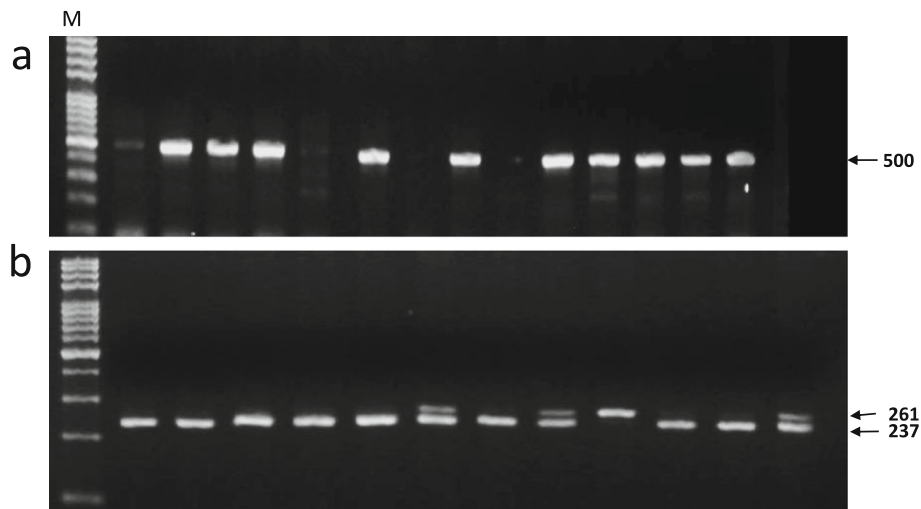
The *HPSE* SNP genotyping from Egyptian patients with HCC and control individuals by agarose gel electrophoresis. a genotyping of *HPSE* rs12331678 by ARMS-PCR as the first 2 lanes are CC genotype and the lanes 3 and 4 are CA genotype. b genotyping of *HPSE* rs12503843 by RFLP-PCR; CC genotype product 237 bp, while CT genotype 237 and 261 bp and TT genotype 261 bp
